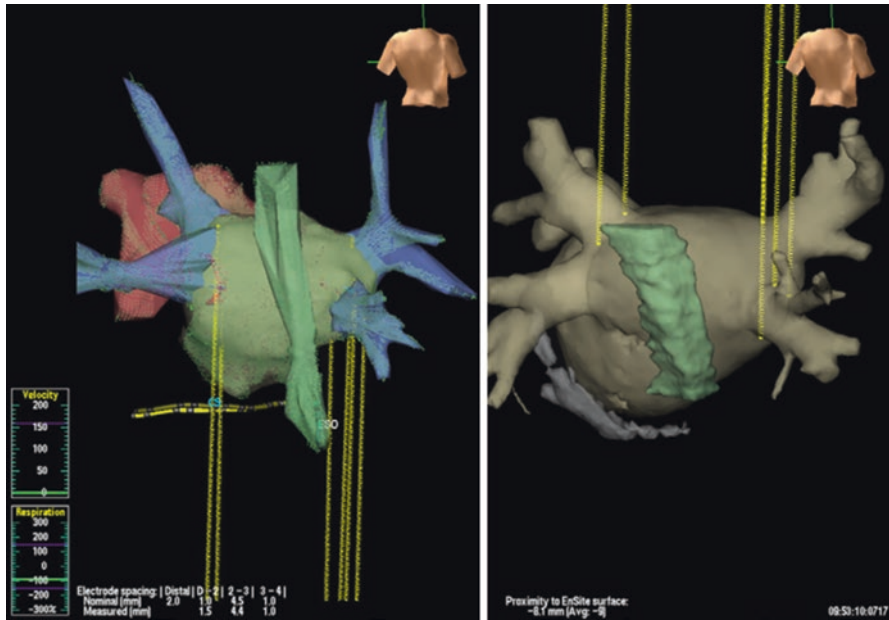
Posterior view of 3D reconstruction images created by electro-anatomical mapping (left) and CT (right). The esophagus is colored green with the globular left atrium immediately anterior. Variable esophageal positioning influences the conduct of radiofrequency ablation of left atrial arrhythmias. The yellow lines represent points of alignment used as a reference to perform image fusion. (With permission from Scuzzuso et al. [37])
